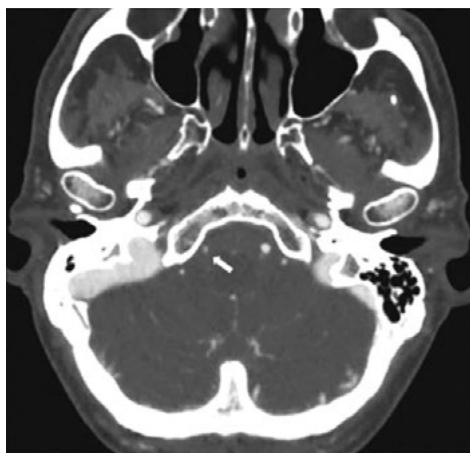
2D Axial Computed Tomography image presenting right VAH (indicated with an arrow). VAH — vertebral artery hypoplasia.
